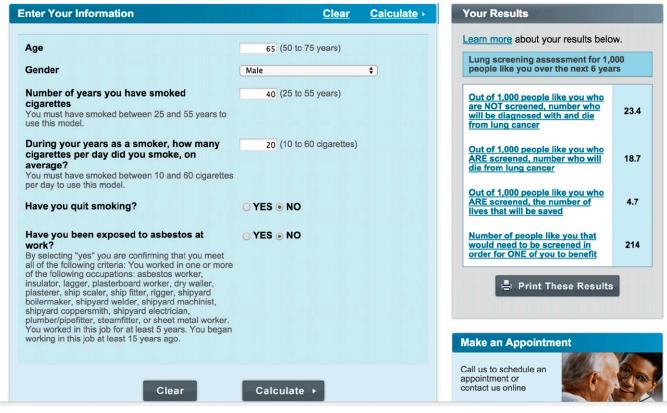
Screen shots of online calculator, developed by the Memorial Sloan Kettering Cancer Center, to predict personalized expected benefits of lowradiation-dose computed tomography screening. This tool is available at http://nomograms.mskcc.org/Lung/Screening.aspx, and the risk prediction model is supported by References 35–37. Reproduced by permission from http://nomograms.mskcc.org/Lung/Screening.aspx.
